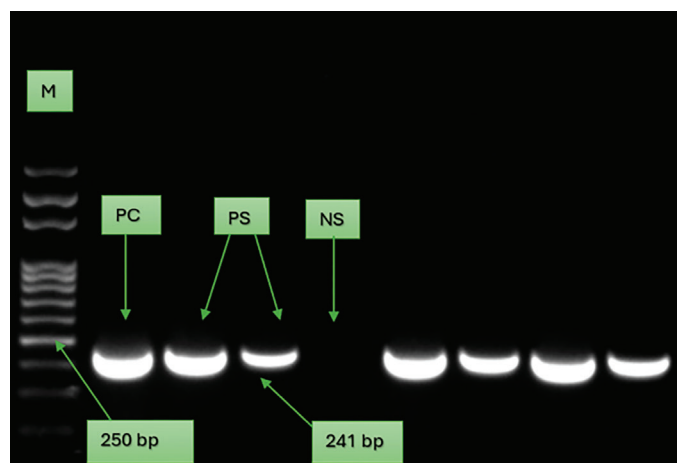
Agarose gel electrophoresis of CT isolates
